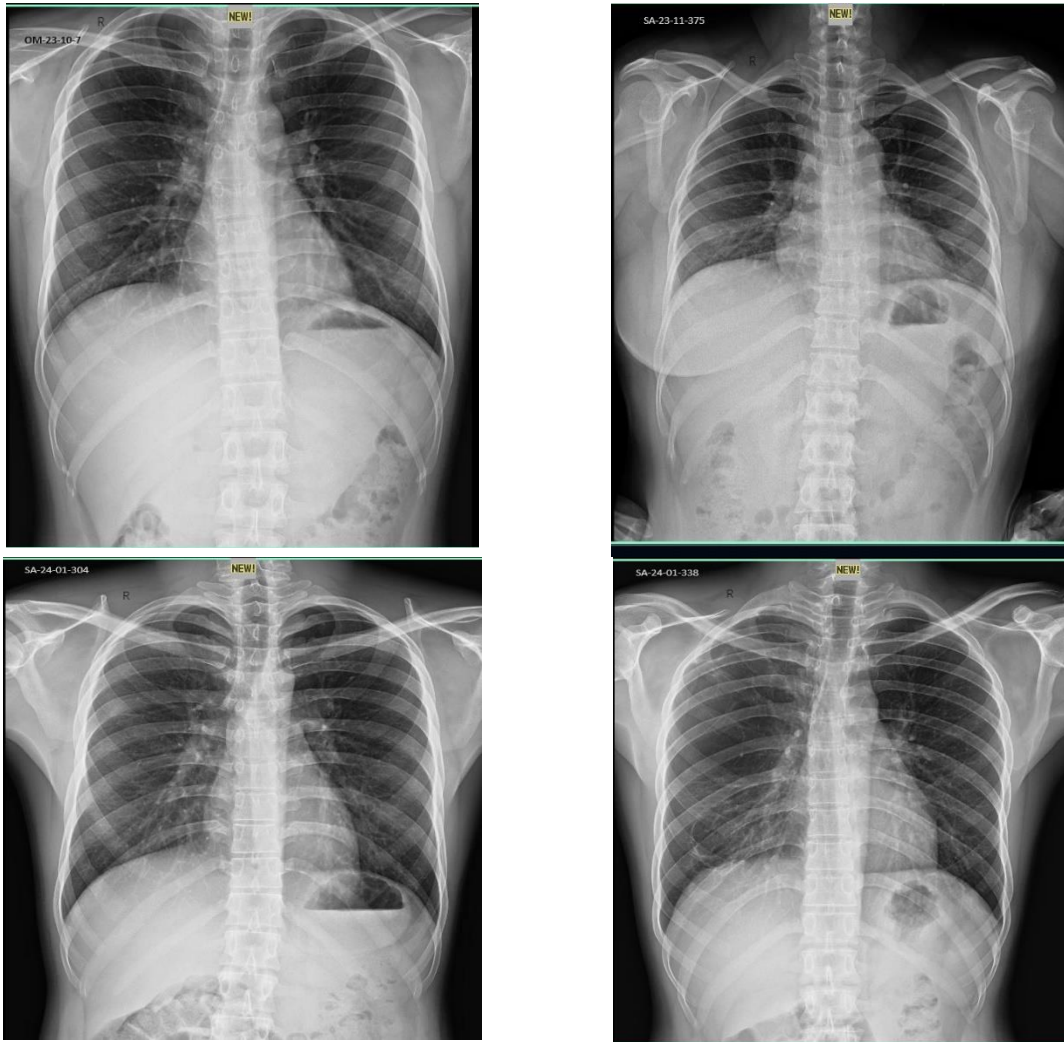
Chest P/A view X-Ray report of TPHA positive and or VDRL reactive patients
